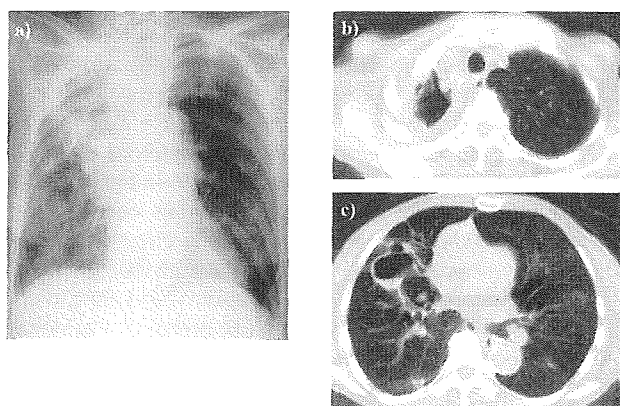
(a) Chest radiograph showing a cavitory lesion in the right upper lung field and infiltrative shadow surrounding the cavitation (Case 3). (b), (c) Chest CT scan showing a cavity with adjacent pleural thickening in the right upper lobe and cavitory infiltrates with fluid collection in the middle lobe (Case 3).
